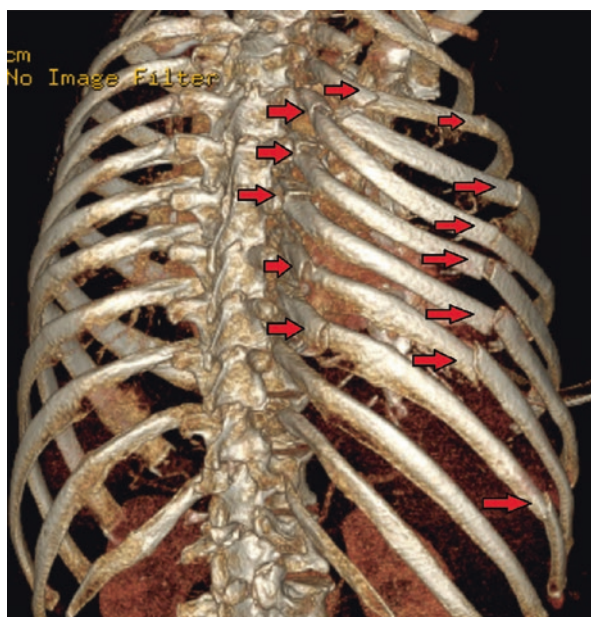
Rib fractures, particularly flail chest, are commonly associated with pulmonary contusion, and thoracic CT scan imaging with bony reformats provides excellent detail of the fracture pattern
